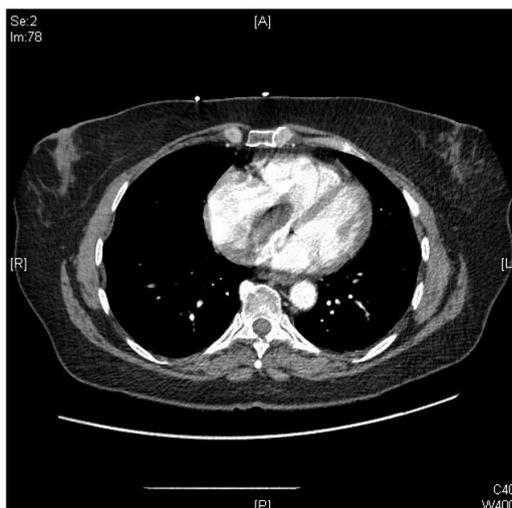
CT angiogram of the chest demonstrates filling defect in the right atrium and right ventricle, representing intracardiac mass.
